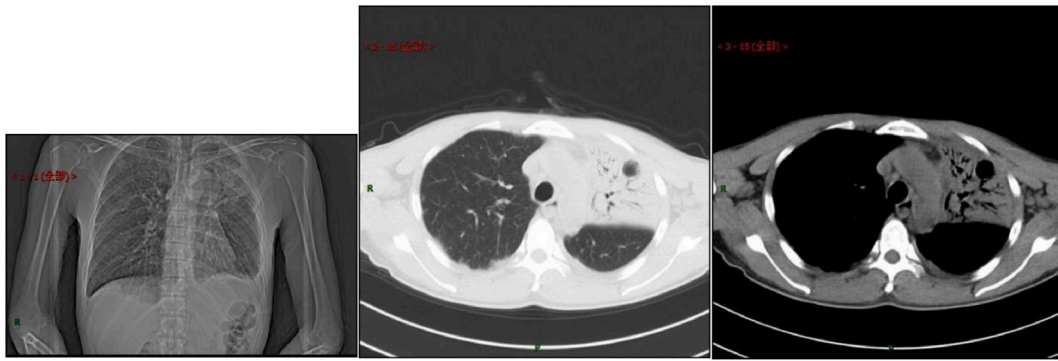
CT done after antibiotics treatment showed no improvement in left lung.
